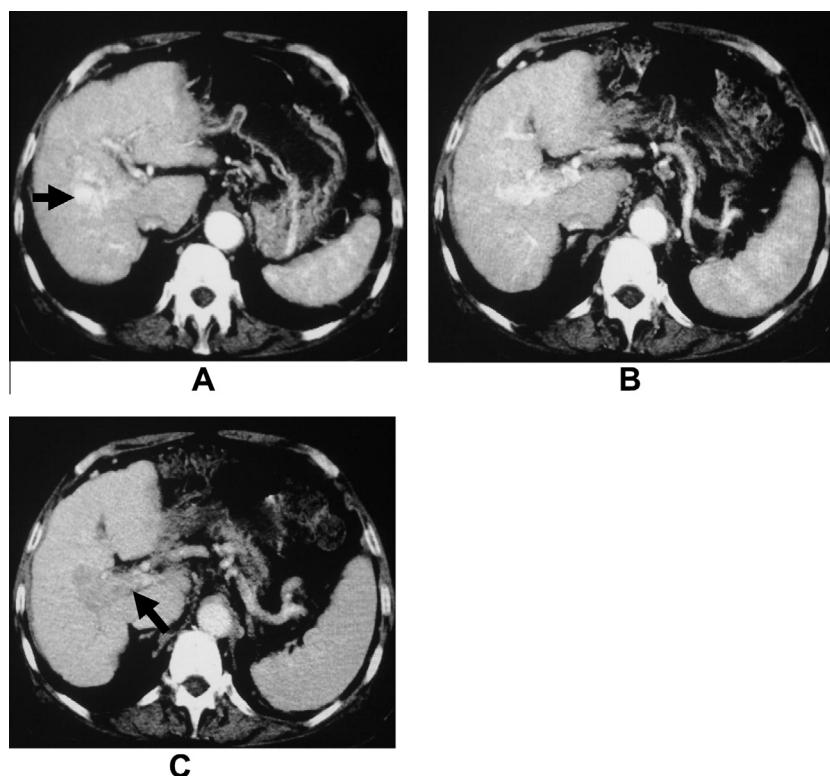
Moderate central APS: 67 year old male patient with liver cirrhosis and nodular HCC at the vicinity of the right main portal vein. (A) Axial CT cut at the late arterial phase shows enhancement of the HCC (arrow). (B) More caudal scan shows shunting of the contrast to the right portal vein. (C) Thrombosis of the right portal vein is confirmed at the portal venous phase (arrow). No intervention could be performed and Sorafenib was recommended for further management.
